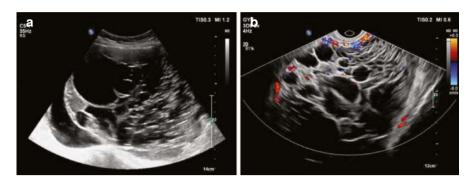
(a) Mucinous cystadenoma showing a large multilocular tumor with poor internal sonolucency. (b) Color Doppler ultrasound shows blood flow within septa
